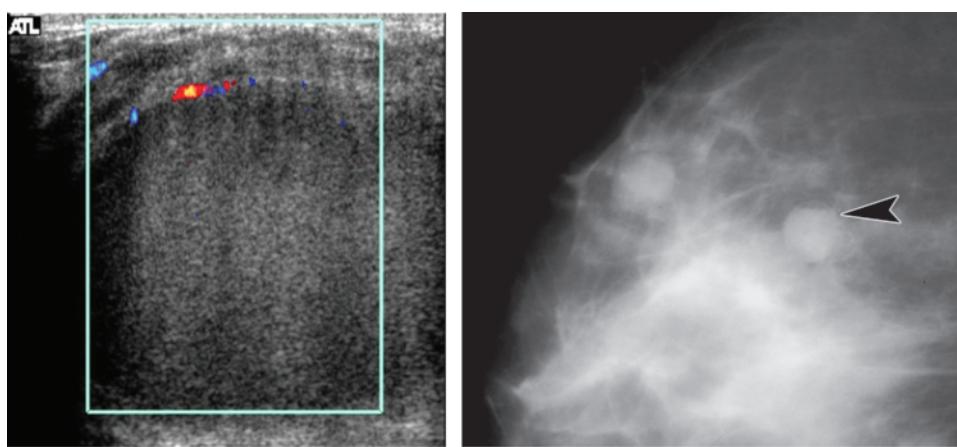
Galactocele in a 15-year-old girl that was confirmed by aspiration of milky fluid. (a) Color Doppler sonogram reveals a well-circumscribed, round cystic structure with homogeneous internal echogenicity, posterior acoustic enhancement, and flow to the cyst wall only. (b) True lateral mammogram of another patient shows the fat-fluid level (arrowhead), which is a specific finding for galactocele.
